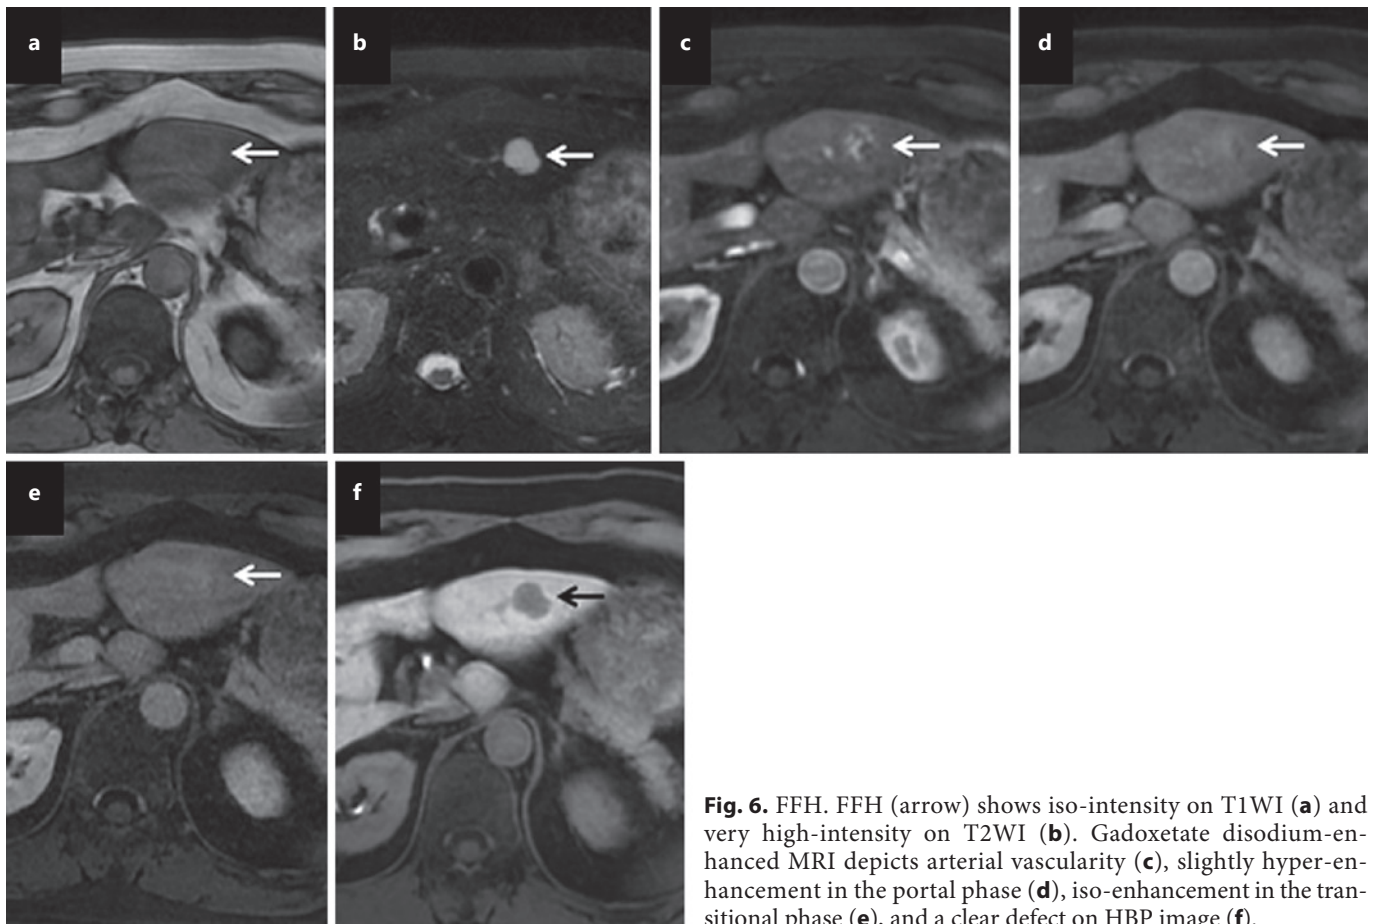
FFH. FFH (arrow) shows iso-intensity on T1WI (a) and very high-intensity on T2WI (b). Gadoxetate disodium-enhanced MRI depicts arterial vascularity (c), slightly hyper-enhancement in the portal phase (d), iso-enhancement in the transitional phase (e), and a clear defect on HBP image (f).
